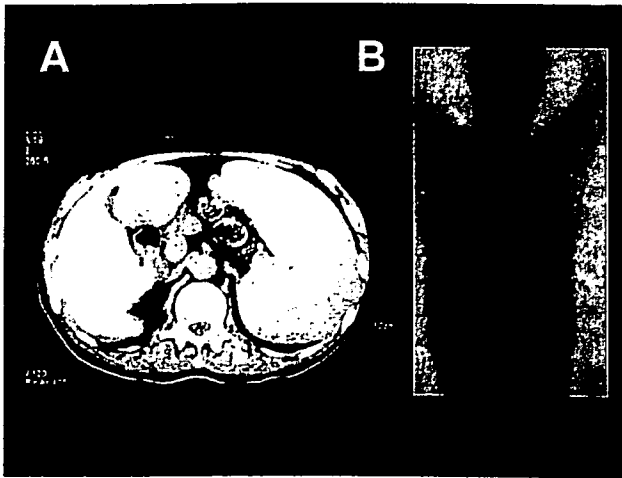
Computed tomography scan showing a markedly enlarged spleen (A). Gallium 67 accumulation in the spleen (B).
